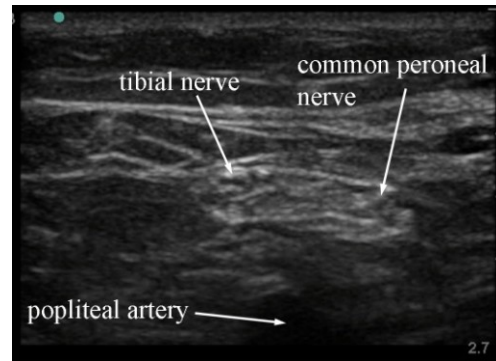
Sonogram of popliteal fossa distal to the division of the sciatic nerve
